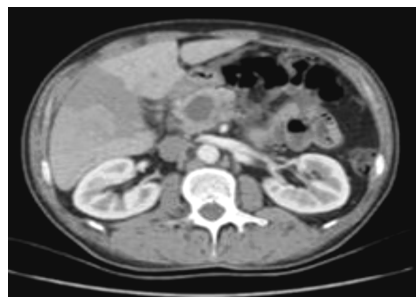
Abdominal CT revealing a cystic pancreatic mass. CT: Computed tomography.
